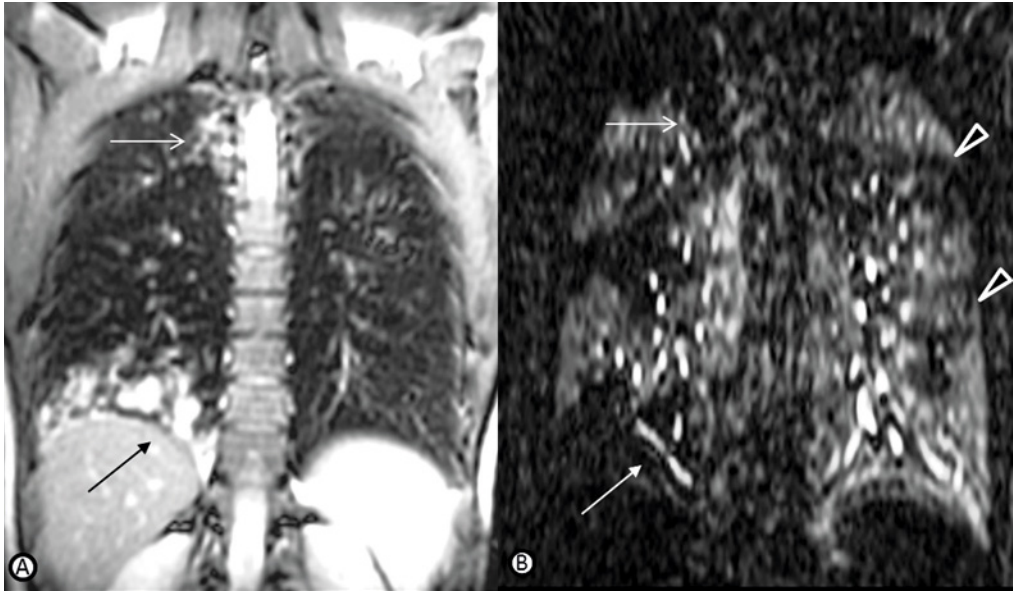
Trapped Air (TA) and Hypoperfusion (HP). (A) end-expiratory coronal 2D Steady-State Free Precession (SSFP) proton-MRI and (B) coronal end-expiratory reformat 3D Spoiled Gradient Echo (SPGR) with TRICKS contrast-enhanced MRI. Note that HP areas often match areas of structural changes as in right upper (open arrows) and lower lobes (close arrows), but that there are also clearly HP on the CEMRI that are apparently free of disease on proton-MRI (arrowheads).
